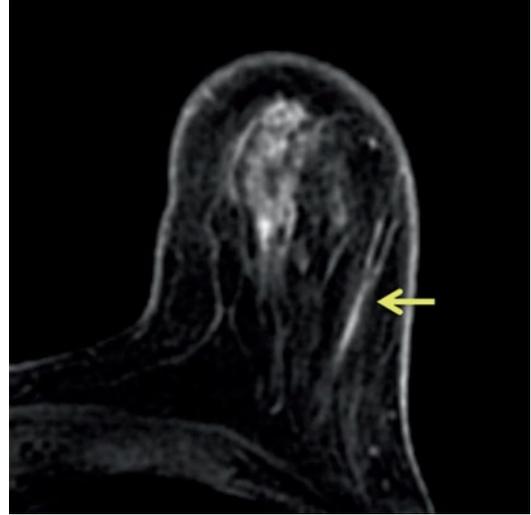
High-nuclear-grade DCIS with comedonecrosis and microcalcifications detected in a 62-year-old woman with high risk for malignancy. Axial post-contrast fat-sat T-1-weighted MR image demonstrates clumped, nonmass enhancement in a segmental distribution. The digital mammogram was negative
